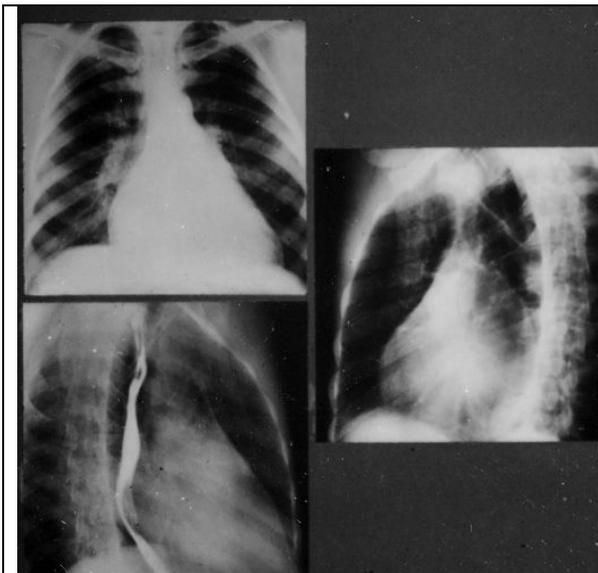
20. Heart radiographs in a direct, right (first) slanting projection, left (second) slanting projection. The mitral configuration of the heart. On the left contour lengthening of the left ventriculus arches, ear of the left auricle, pulmonary artery is detected. On the right contour the arch of the right auricle is increased. In the right (first) slanting projection on the arch of small radius (<6 sm) the contrasted oesophagus is displaced due to the increased left auricle, increases the left ventriculus arch. In the left (second) slanting projection on a forward contour the arch the bottom arch right ventriculus is increased. On a back contour arches of the left auricle and left ventriculus are extended. Mitral regurgitation and mitral stenosis.
